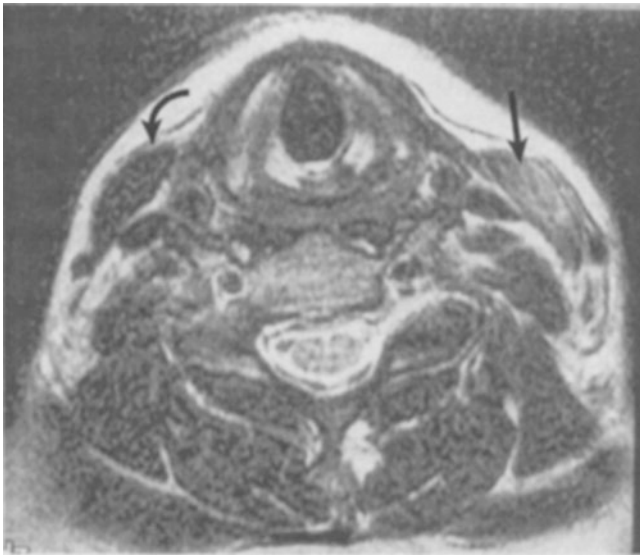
T2-weighted axial image at the level of the sixth cervical vertebra, demonstrating local anesthetic myotoxicity. The patient had received intercostals bupivacaine 45 days before and complained of left neck pain. The left sternocleidomastoid muscle (*straight arrow*) is enlarged and shows uniformly increased signal intensity indicative of the elevated fluid content from edema
